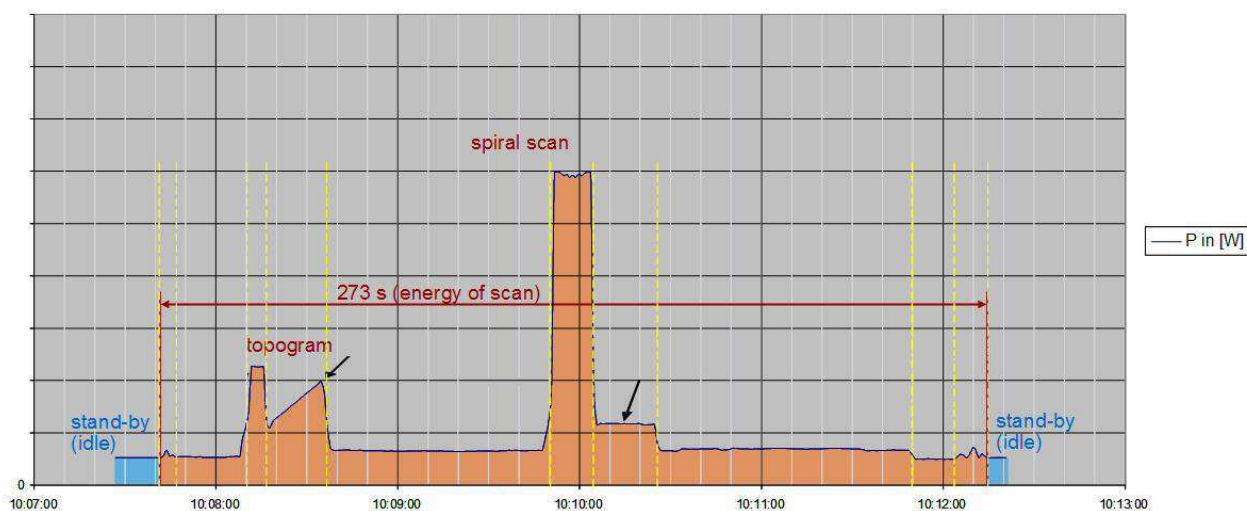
Exemplary power consumption of CT during scan
